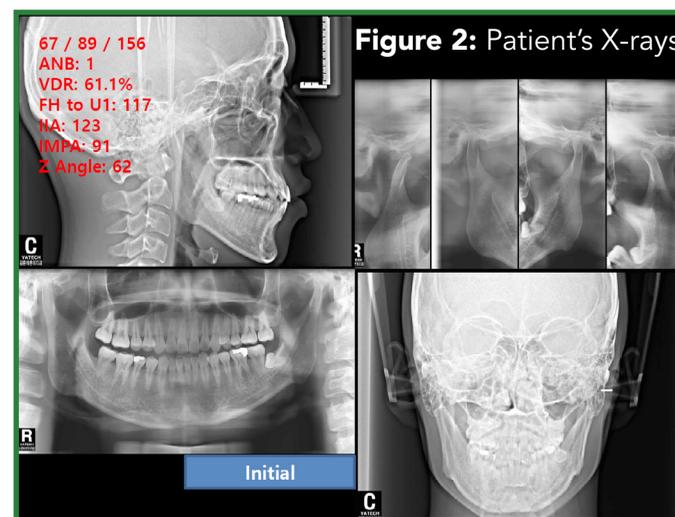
Patient's X-rays
